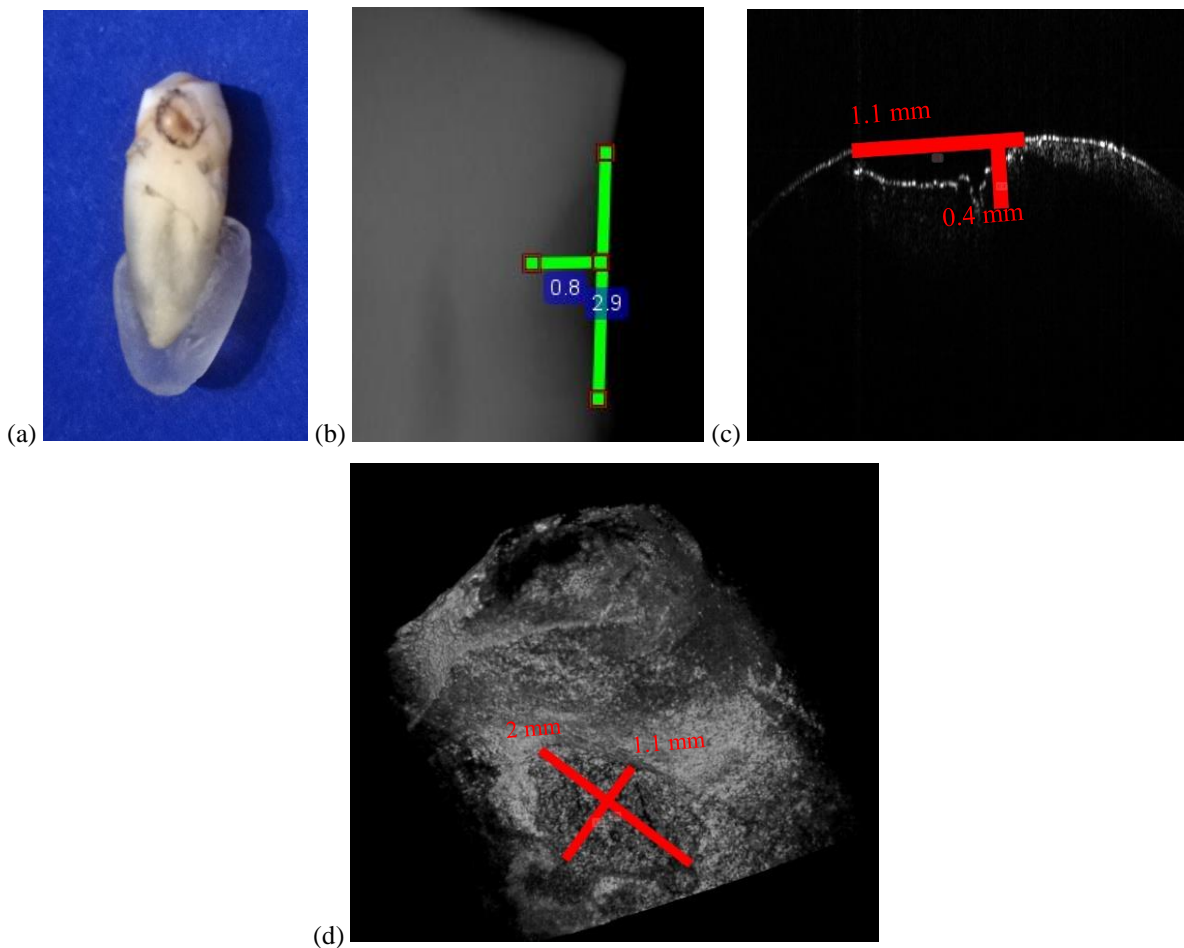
(a) tooth number 13, marked for OCT investigations; (b) a section from the intraoral radiograph with a focus on the measured cavity; (c), (d) XY and XZ sections from an OCT image where the measurements of the cavity were done. (d) is a volumetric reconstruction after OCT investigation, where 2 cavities are marked: one is a cavity in the early stages and the other one is the cavity from the previous views.
